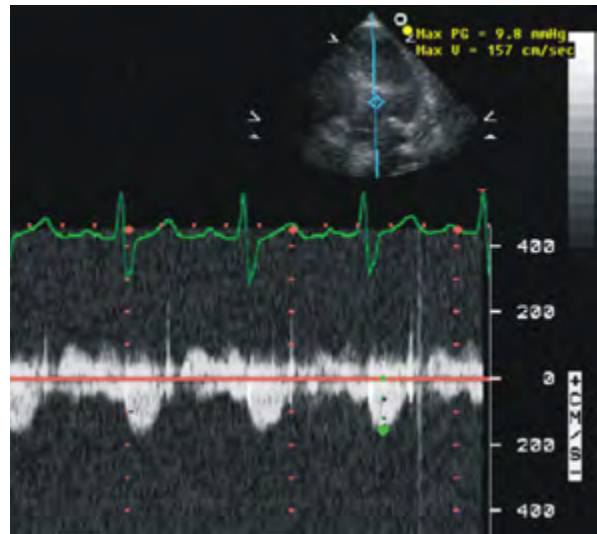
Transthoracic echocardiograms 2 weeks after alcohol septal ablation show A) a low peak instantaneous resting left ventricular outflow tract gradient of 9.8 mmHg, and B) trivial mitral regurgitation (color-flow Doppler mode).
